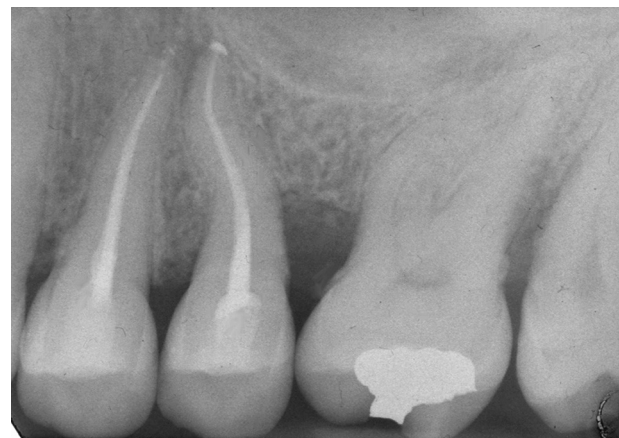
Post-operative radiograph of 2.4 and 2.5. Shaping was obtained with ProTaper Next.
